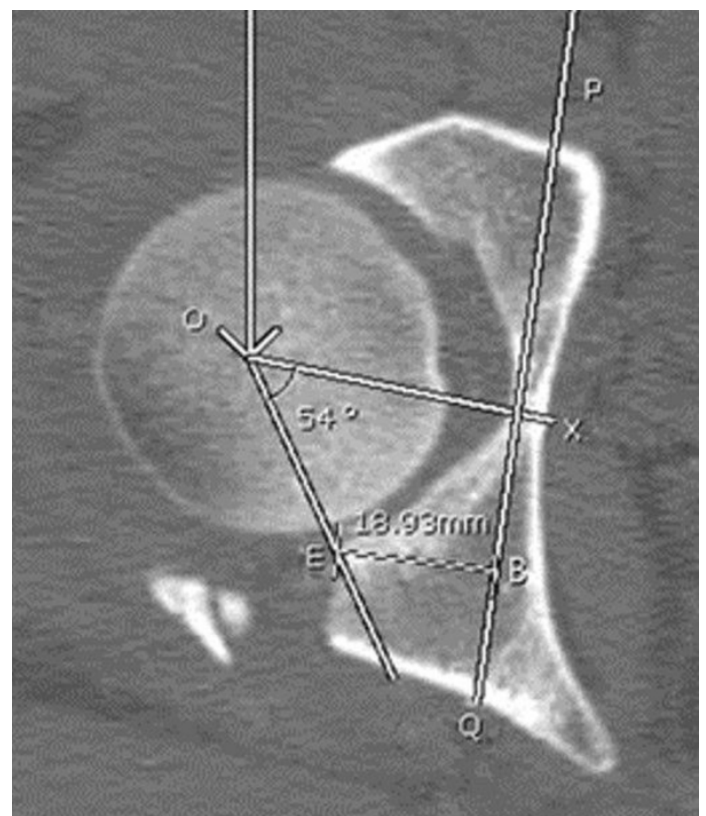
The photograph of computed tomography imaging Coronal PAAA (9).
